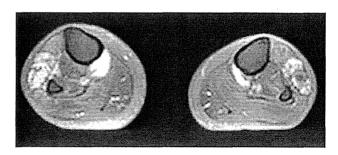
Muscle MRI T1 transverse images at calf level in patient 8. The anterior tibial muscle is mainly involved.
